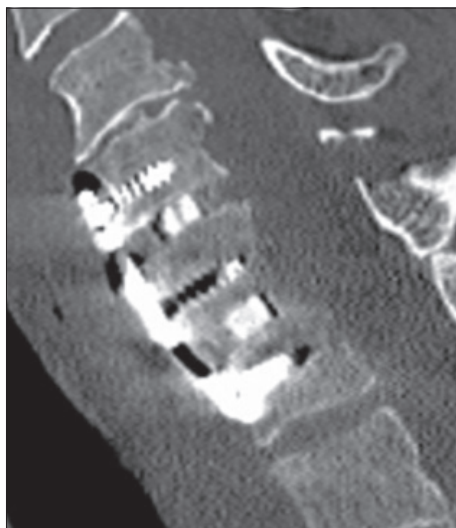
Postoperative CT scan showing the state after C6-C7-Th1 stabilisation
